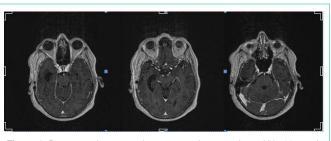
Post-operative magnetic resonance images taken within 12 month of surgery show no evidence of local recurrence.
